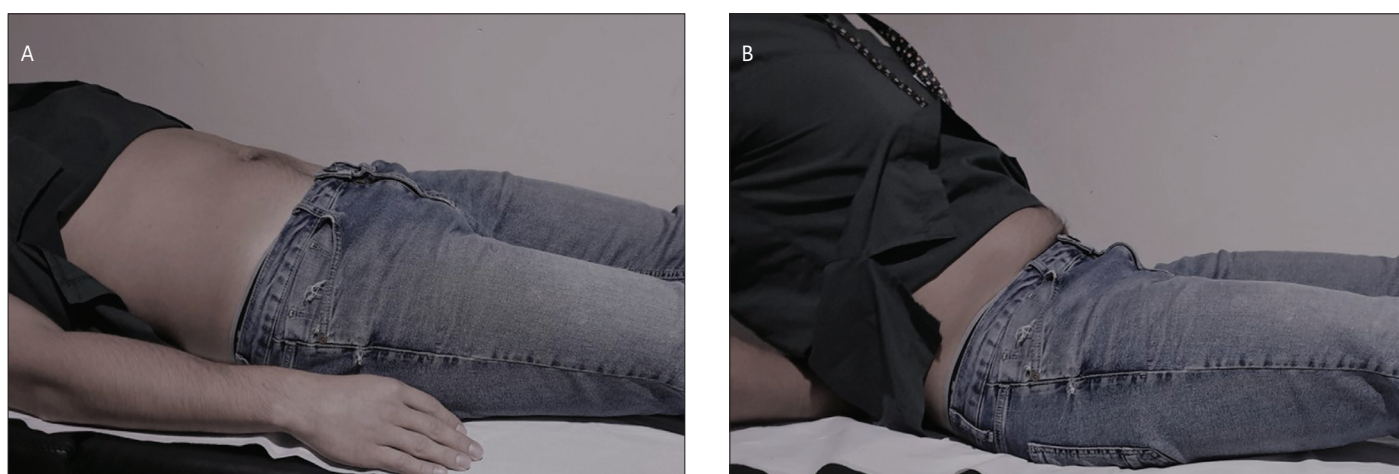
A case of a 26-year-old man diagnosed with an IH; ultrasound measurements were taken in the (A) supine and (B) semi-erect (45°) positions.
